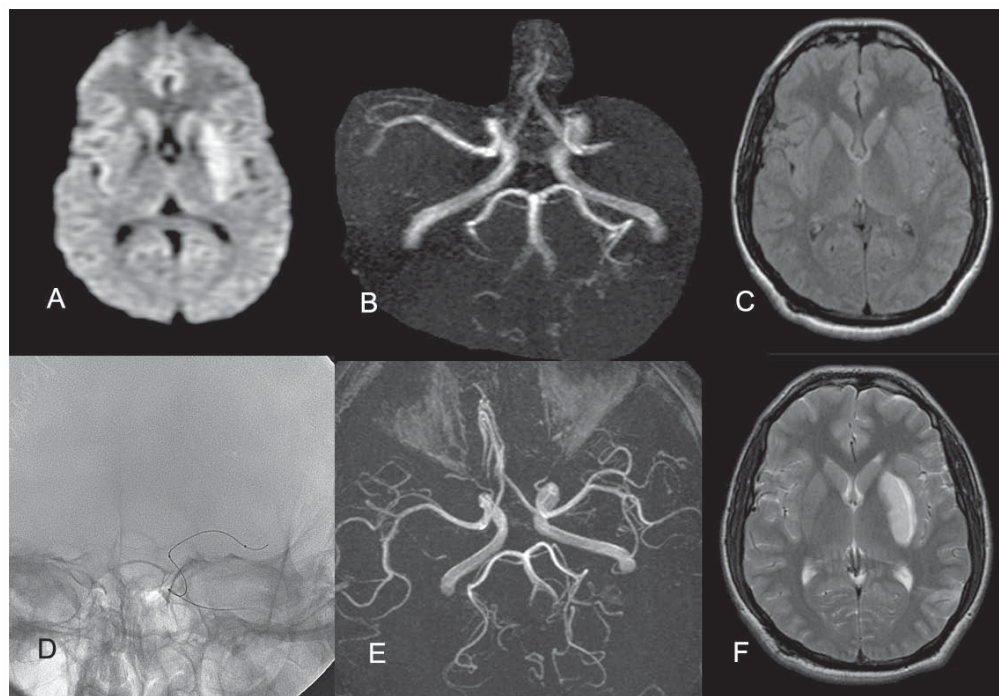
Acute stroke. Diffusion weighted image and MR angiogram show acute infarct in left lentiform nucleus due to middle cerebral artery occlusion (A, B & C). Intra-arterial thrombolytic therapy (D) with micro-catheter and micro-guidewire positioned across the occlusion. Follow up MRI and MR angiogram (E & F) reveal complete recanalization of left middle cerebral artery and infarction limited to the lentiform nucleus.
